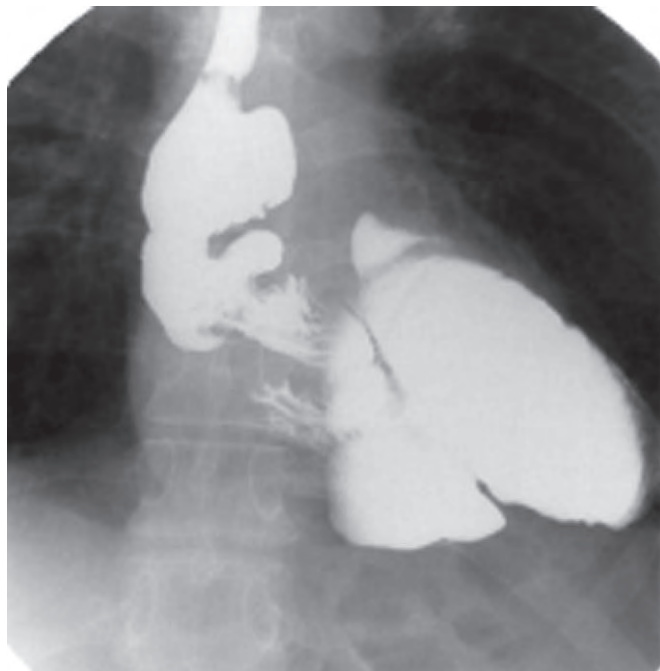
Left colon interposition. Postoperative contrast upper gastrointestinal radiograph of the patient in Figure 20-12 demonstrating the intact reconstruction.
